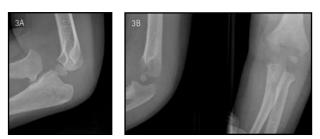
A. In this elbow radiograph, a positive posterior and a positive anterior fat pads are seen, but no fracture can be found. B. followup radiographs a few weeks later shows humerus metaphyseal bone destruction from osteomyelitis. Joint infection is also a cause of positive elbow fat pad signs.
